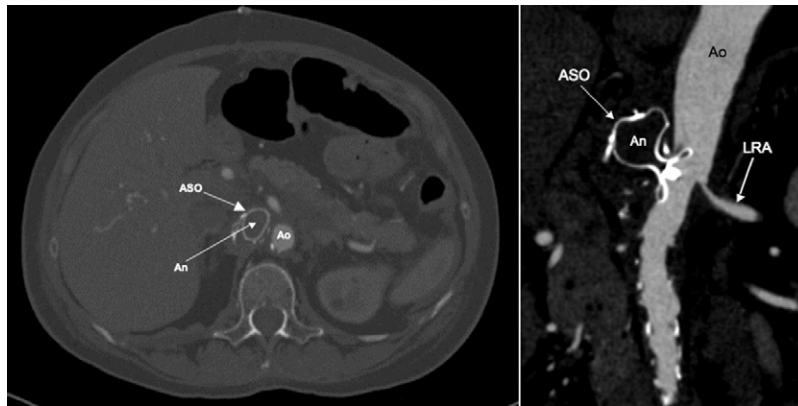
A computed tomography angiography shows the left renal artery (*LRA*) and the atrial septal occluder (*ASO*) device in the successfully thrombosed saccular aneurysm (*An*).
